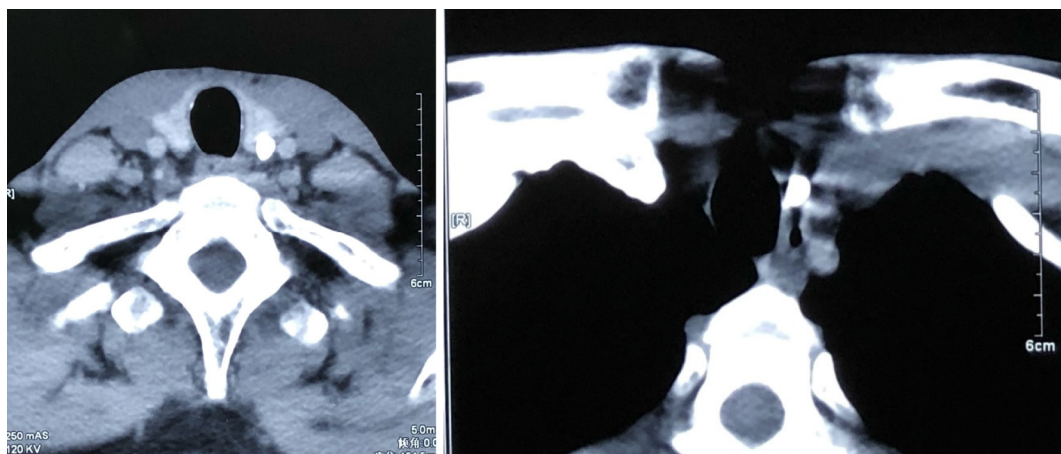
Axial cervical computed tomography scan demonstrated a high density in the anterior area of the neck and the upper mediastinal area and near the left arteria carotis communis.
